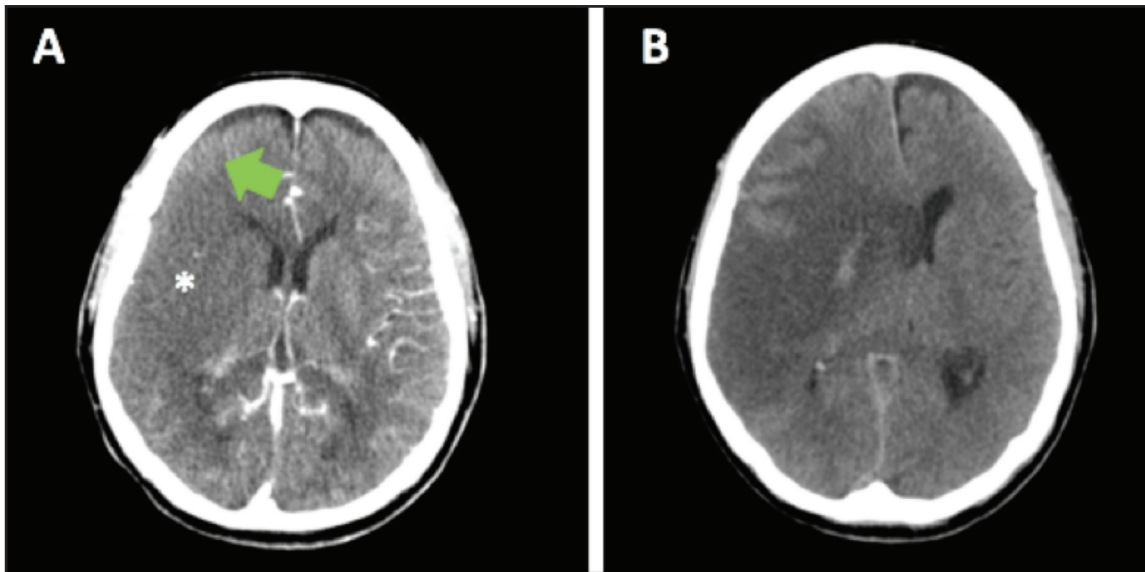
CT imaging of brain. (A) Showed acute right MCA infarct with effacement of sulci (Green arrow) and loss of grey white matter differentiation (*). (B) Showed haemorrhagic transformation with mass effect on previous right MCA infarct territory.
